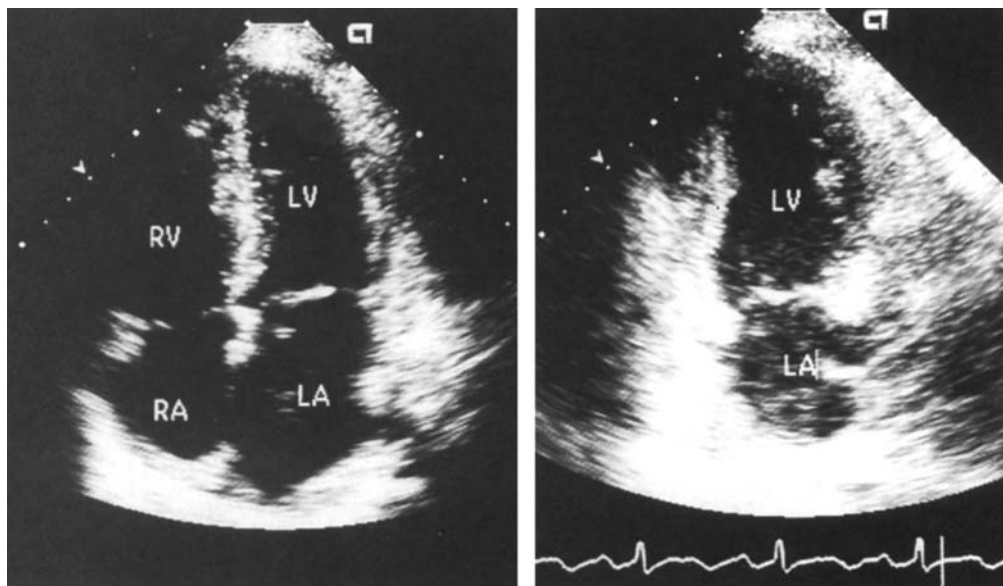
Apical four- and two-chamber views of the left ventricle. Note the normal “bullet shape” geometry of the left ventricle and the more triangular right ventricle. Note also the more apical insertion of the tricuspid valve compared with the mitral valve. (From Braunwald, E., Zipes, D.P., and Libby, P., *Heart Disease: A Textbook of Cardiovascular Medicine*, Philadelphia: W. B. Saunders, 2001.)
